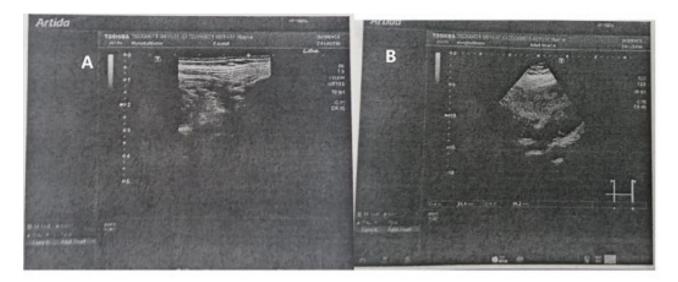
Structural heart prompted echocardiography showed no abnormalities.
